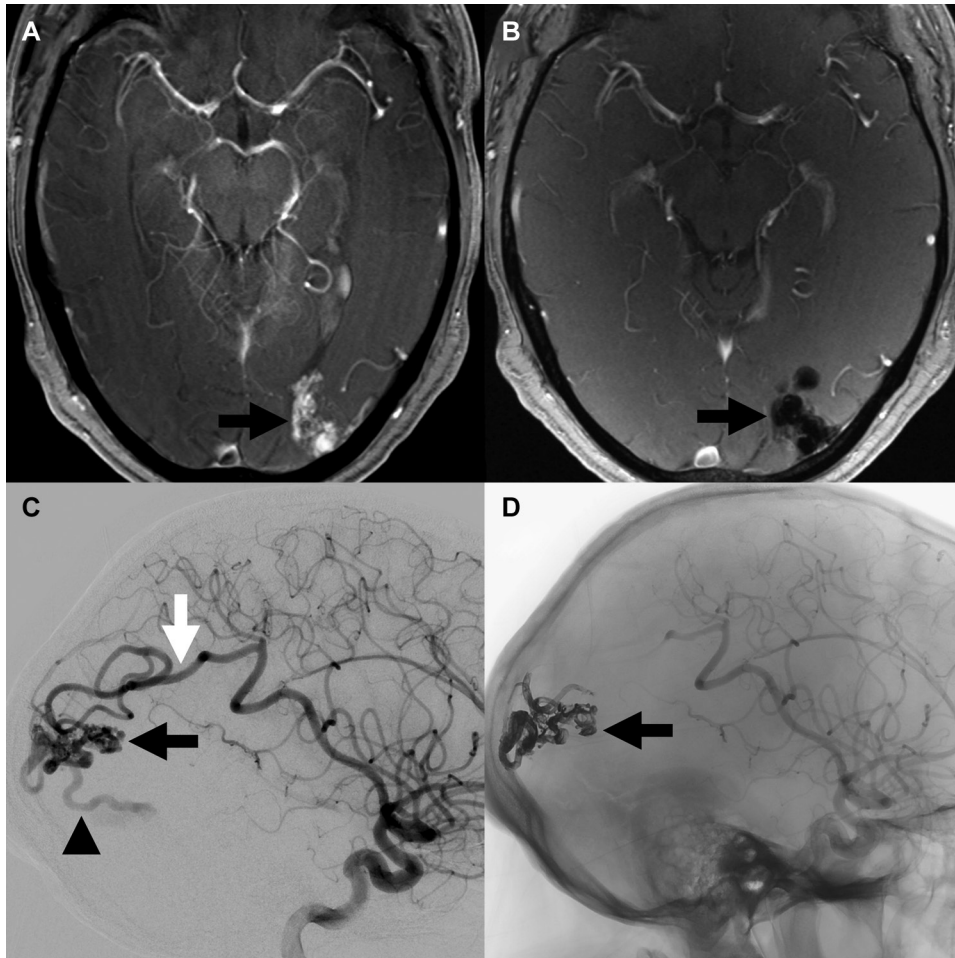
Example of an arteriovenous malformation. Pre- (A, C) and post-interventional (B, D) images of a patient with a symptomatic, unruptured AVM. In the contrast-enhanced TOF angiography before treatment, the nidus of the AVM is visible as multiple contrast-enhancing small tubular structures, the so-called nidus (arrow in A). Pre-interventional DSA shows feeding arteries from a branch of the middle cerebral artery (white arrow in C) supplying the nidus (black arrow in C) and venous drainage into the superficial venous system (black arrowhead in C). After embolization with a liquid embolic agent, which is visible as hypointense material in MRI (arrow in B), the AVM is completely occluded (radiopaque cast of liquid embolic agent in D). AVM: arteriovenous malformation; DSA: digital subtraction angiography; MRI: magnetic resonance imaging; TOF: time-of-flight
